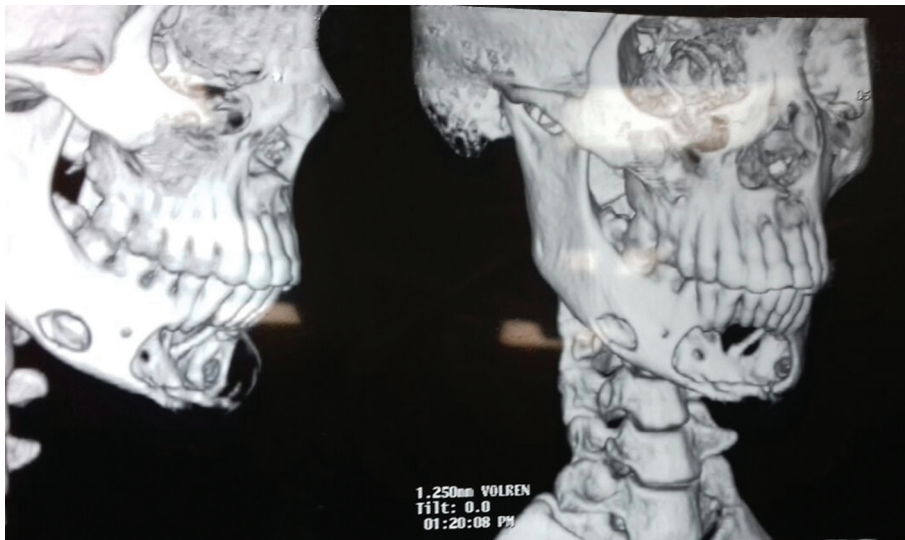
CECT face showing lesion extending from right premolar to left incisor along with skip lesion. CECT, contrast-enhanced computed tomography.
